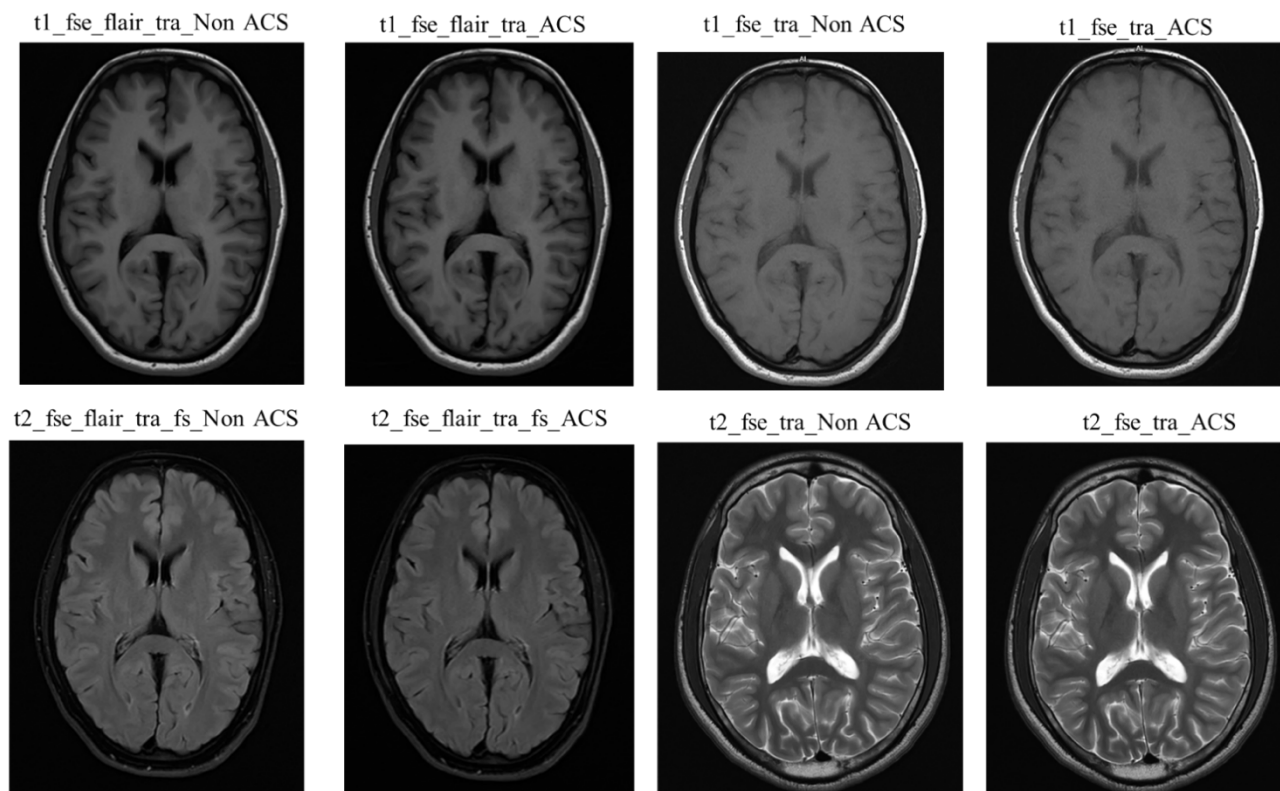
Brain MRI slices for all sequences of a representative subject.
